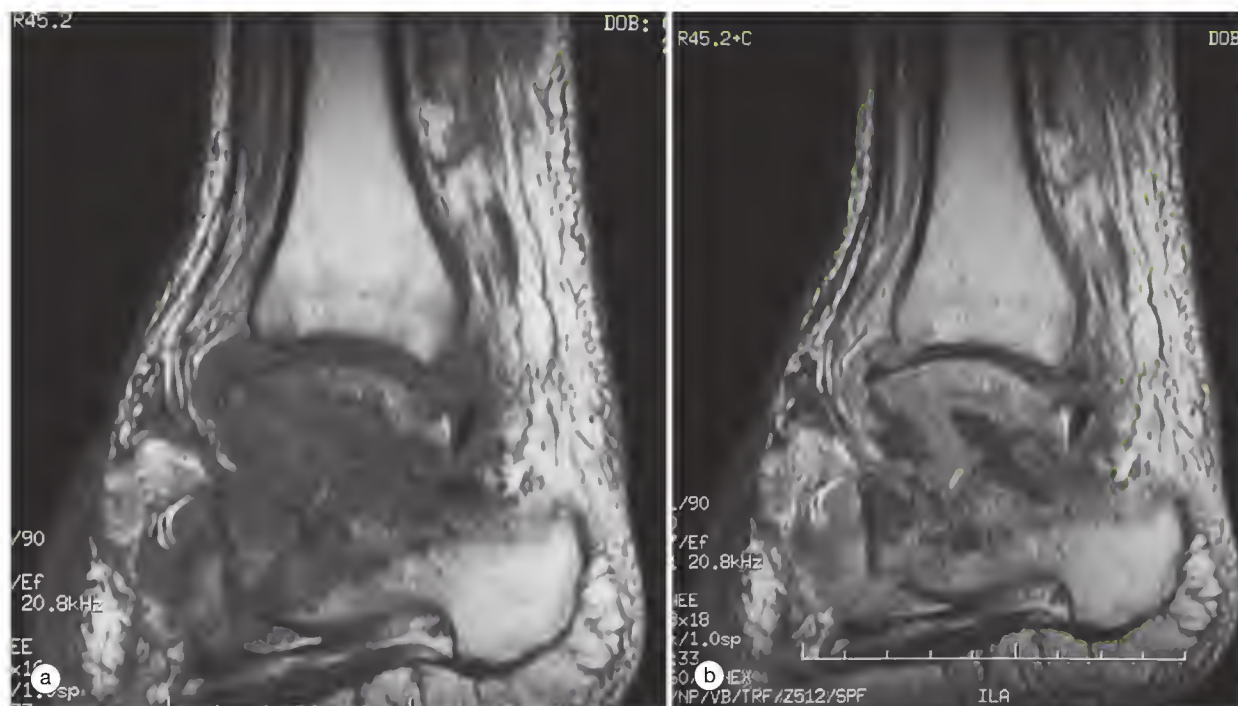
Septic arthritis of the ankle complicated by osteomyelitis. (a) A sagittal T1-weighted spin-echo magnetic resonance image shows severe destruction of the subtalar joint with bone involvement. (b) Contrast-enhanced T1-weighted spin-echo magnetic resonance image shows generalized enhancement of both synovial and bone tissues and abscess formation into the talus and calcaneus.
